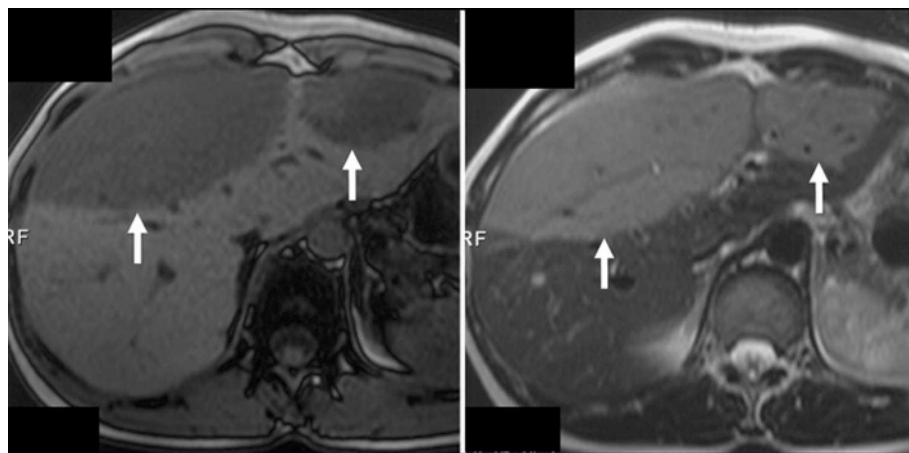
Magnetic resonance scans confirming the presence of ultrasound/computed tomography detected area (white arrows), which appears hypointense at T1 (A) and hyperintense at T2 (B) weighted acquisition.
